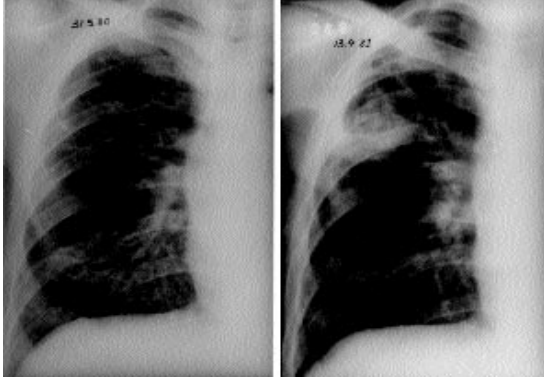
Case 8 - Chest x-ray showing a fungus ball within a cavitation that appear in a healthy lung parenchyma.
